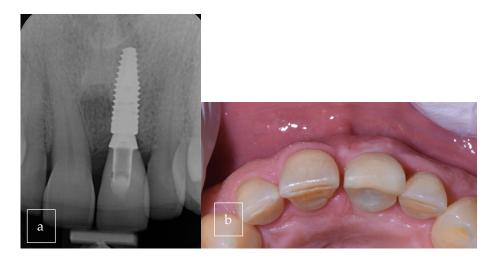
Radiographic (a) and clinical examination (b) at 3-year follow-up period.
